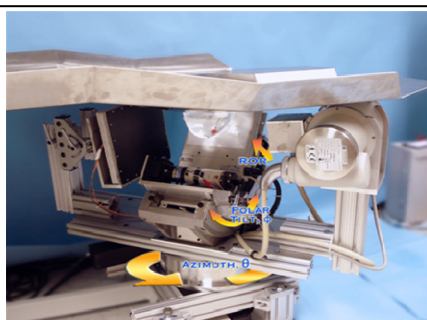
Image of the custom designed patient bed positioned over the initial prototype integrated SPECT-CmT imaging system.
